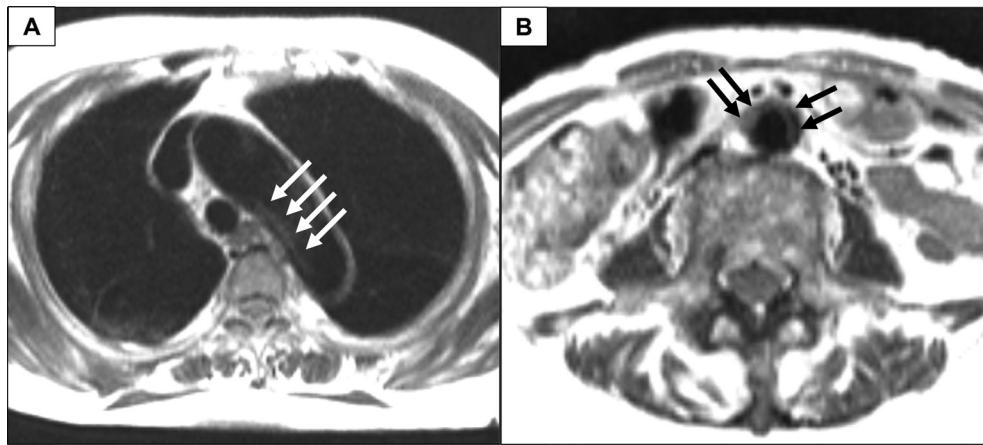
Findings of magnetic resonance imaging. Magnetic resonance imaging of the thoracoabdominal aorta. Atherosclerotic and calcified plaque (arrows) are detected in the aortic arch and abdominal aorta (A and B).
